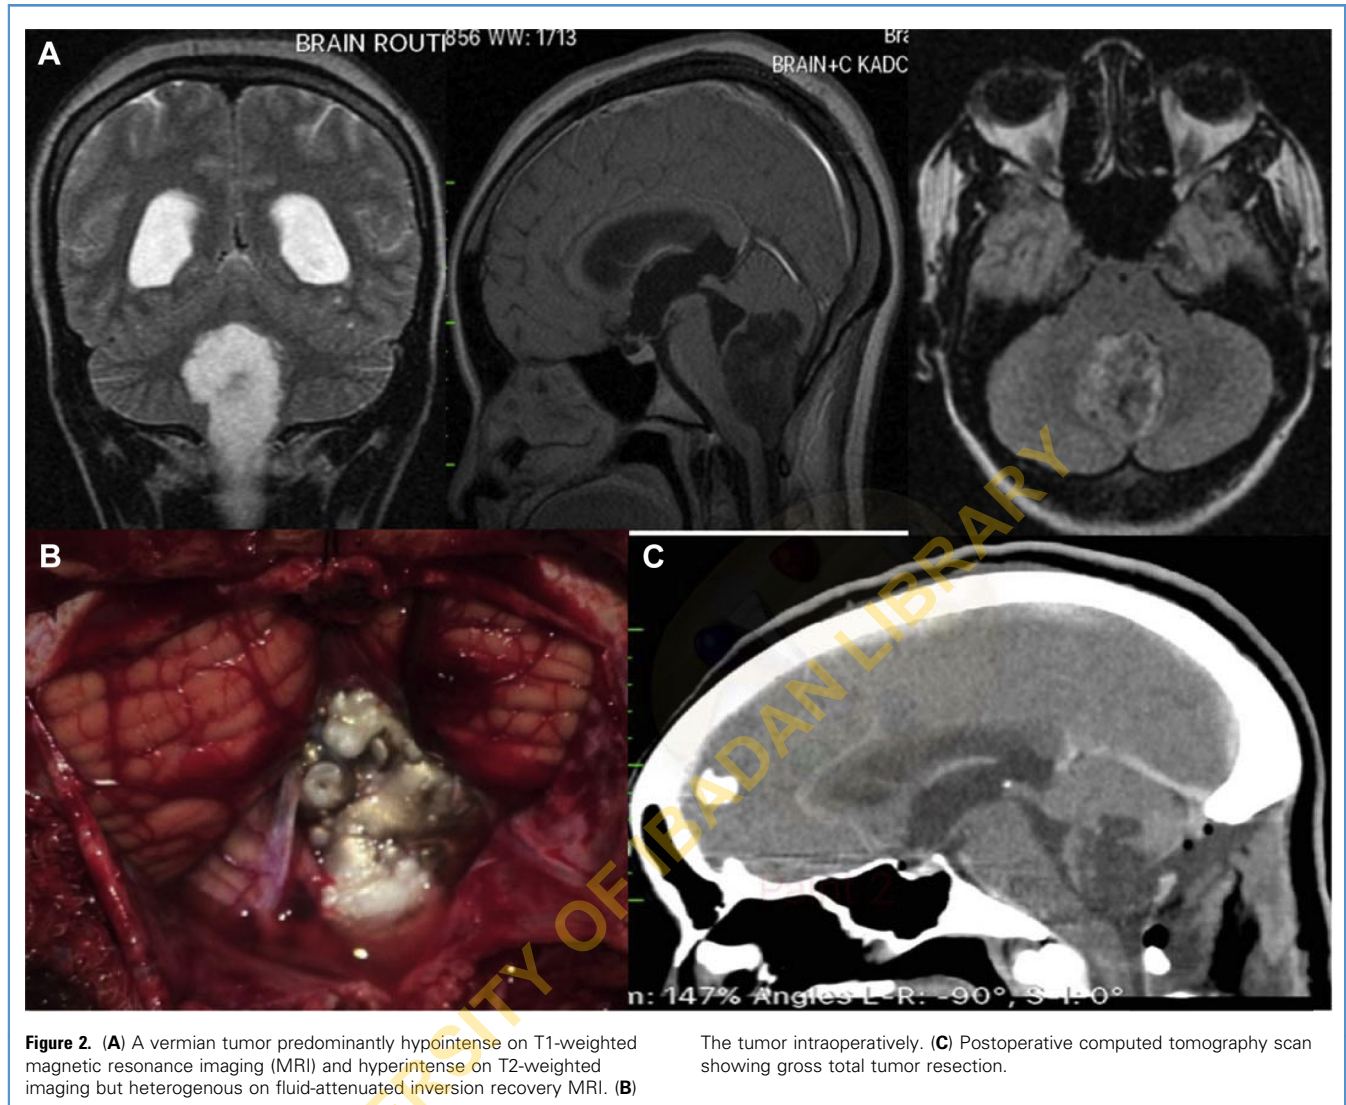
(A) A vermian tumor predominantly hypointense on T1-weighted magnetic resonance imaging (MRI) and hyperintense on T2-weighted imaging but heterogenous on fluid-attenuated inversion recovery MRI. (B)
